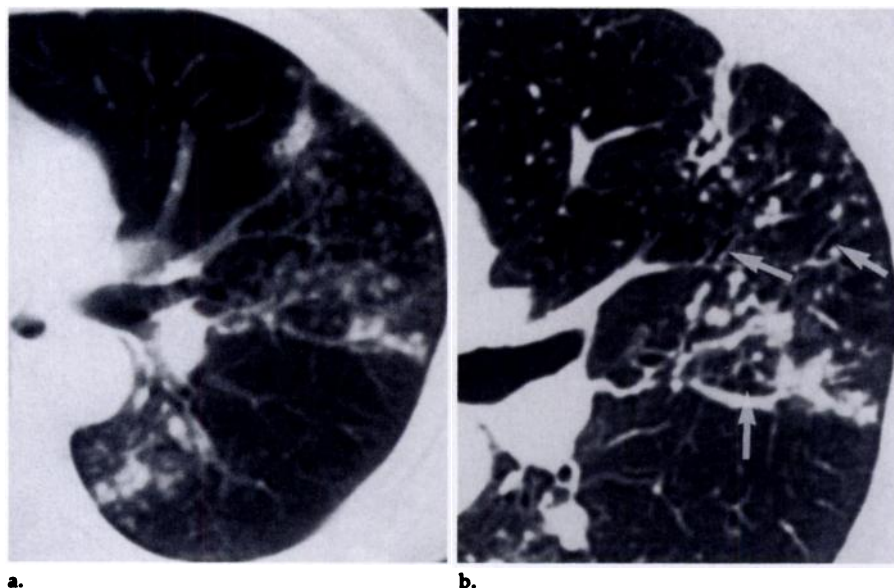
(a) Conventional CT and (b) HRCT scans obtained at the same level of the left lung in a 69-year-old woman. Nodular infiltrate is seen in both a and b, but it is more readily appreciated in a. Bronchiectasis is evident only in b (arrows). (Reprinted, with permission, from reference 15.)
